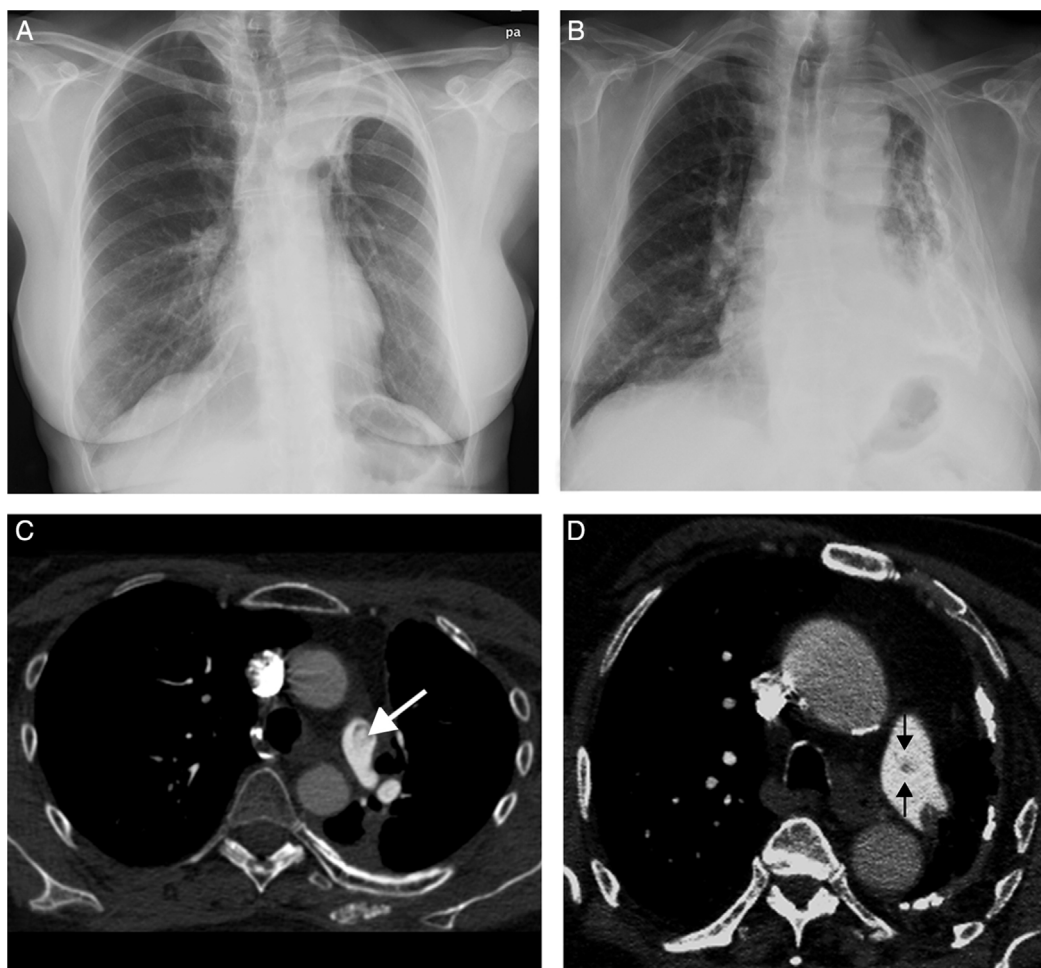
(A) Posteroanterior chest X-ray of a 52-year-old patient (henceforth patient X) with a history of lung cancer treated with chemotherapy and radiation therapy 7 years previously, showing complete atelectasis of the left upper lobe. (B) Posteroanterior X-ray of an 85-year-old patient (henceforth patient Y), showing extensive left pleural thickening and calcification and significant loss of volume in the ipsilateral hemithorax. (C) Axial CT of patient X apparently showing a filling defect in the left main pulmonary artery (arrow), mistakenly interpreted as PTE. (D) Axial CT of patient Y apparently showing another filling defect in the left main pulmonary artery (arrows) that was also mistakenly interpreted as PTE.
